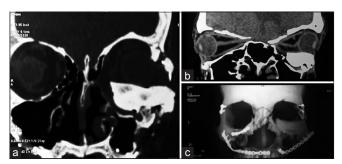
(a) Coronal computerized tomography scan showing a hyperdense mass on the left orbital floor, (b) reconstructed parasagittal CT scan showing inferiorly displaced left orbital floor fracture fragment into maxillary sinus with the mass extending from rim beyond the mid-orbit level pushing the globe superiorly, (c) 3D reconstructed CT scan showing plates and screws placed in both anterior walls of the maxilla; right inferior orbital rim and bilateral fronto-zygomatic sutures
